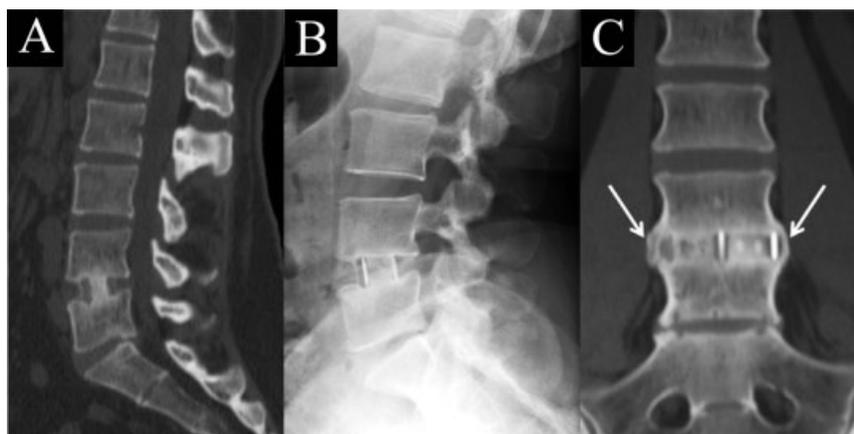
Case 3. Early fusion in rh-BMP2 case. (A) Sagittal view of a computed tomography (CT) scan at 6 months. (B) Lateral x-ray at 9 months. (C) Coronal view of a CT scan at 12 months. Note bilateral sentinel signs (white arrows).
